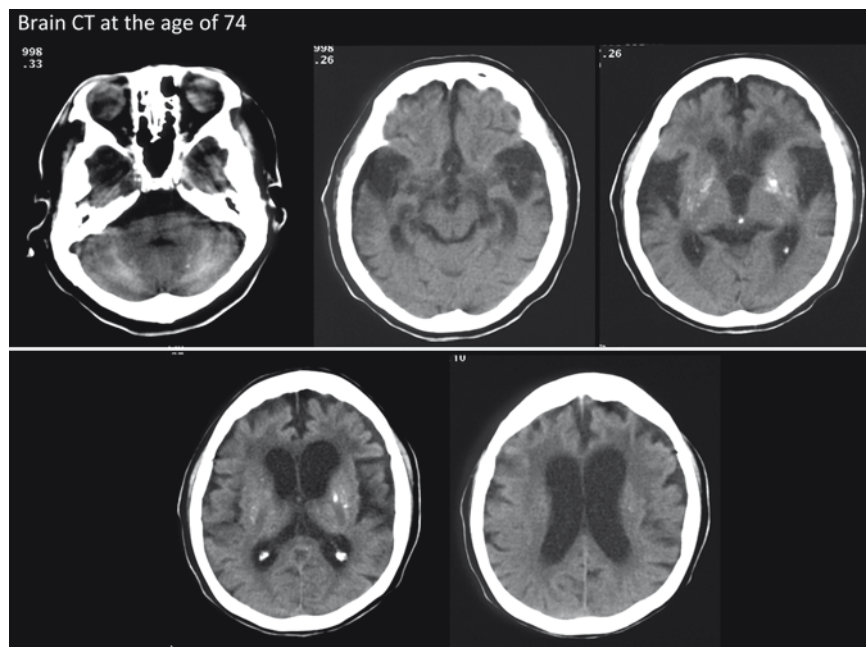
Brain computed tomography (CT) at the age of 74 (case 21). Cerebral atrophy of temporal and frontal lobes and calcification in the basal ganglia and cerebellum
